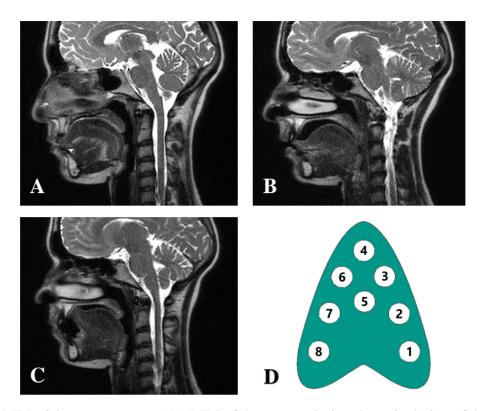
MRI of the tongue at rest (A), MRI of the tongue during the articulation of the phoneme /d/(B), MRI of the tongue touching the center of the palate (C), and map of the 8 positions on the palate (D).
